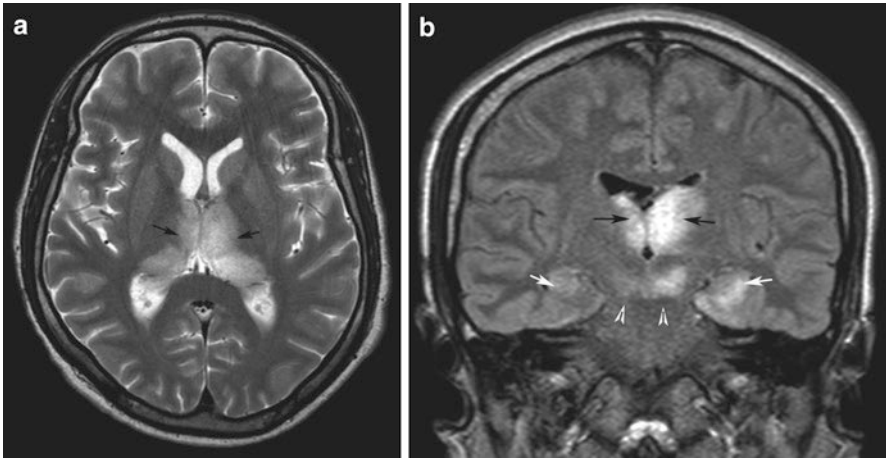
A 50-year-old male with Japanese encephalitis. (a) T2-weighted axial MRI image showing bilateral thalamic lesions (*black arrows*). (b) Coronal fluid-attenuated inversion recovery sequence showing bilateral thalamic (*black arrows*), hippocampal (*white arrows*), and substantia nigra (*white arrowheads*) lesions. The lesions are asymmetric, even though they are bilateral and have local mass effect
